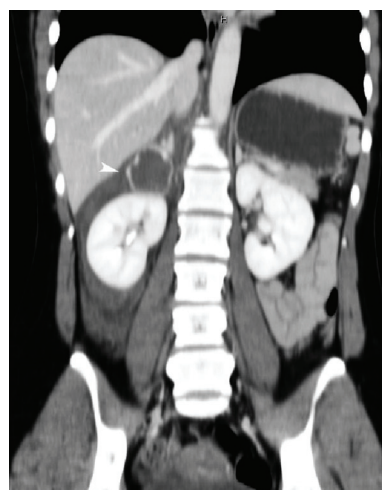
The CT scan abdomen shows a rim enhanced heterogeneous hypo-hyperdense lesion at the right suprarenal region (arrowhead).
